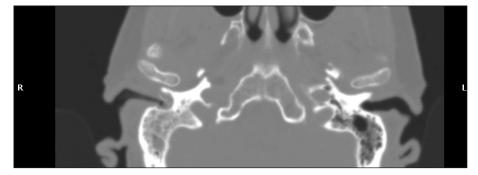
Preoperative CT scans in patient C, axial view, showing a soft tissue mass in the right EAC with destruction of the posterior ear canal wall.
